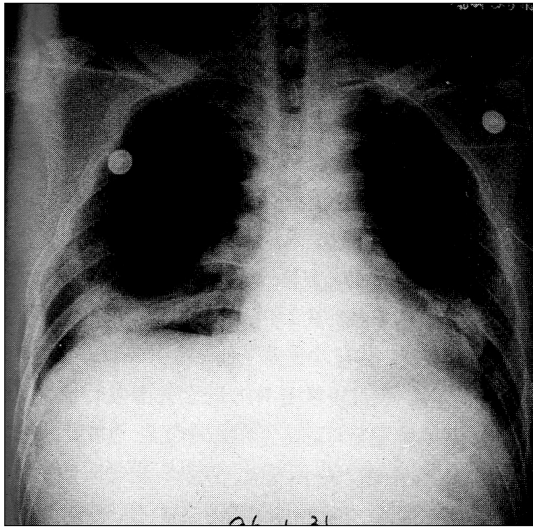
Chest radiograph shows multiple rib fracture and haziness in right lower lung field due to hemothorax.
